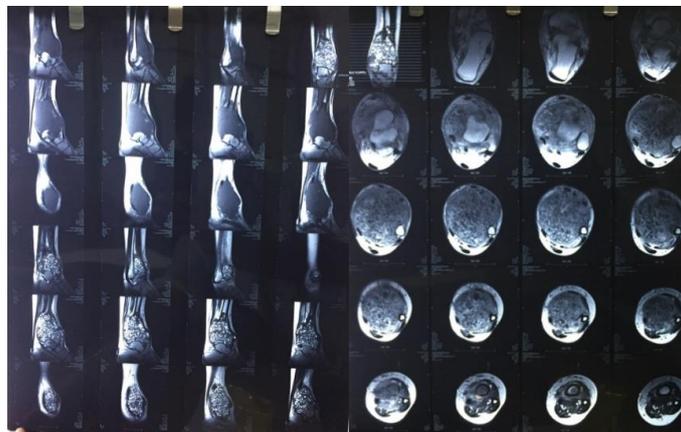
The MRI results indicate a solid mass in the distal tibia measuring 7.1 cm x 7.9 cm x 11.3 cm, with clear borders around the tumor.
